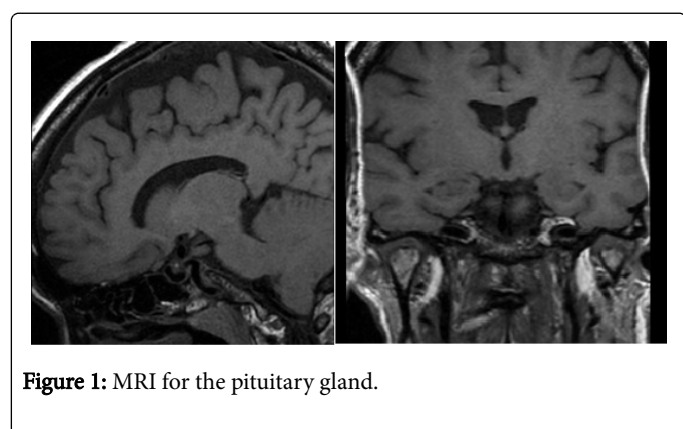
MRI for the pituitary gland.
